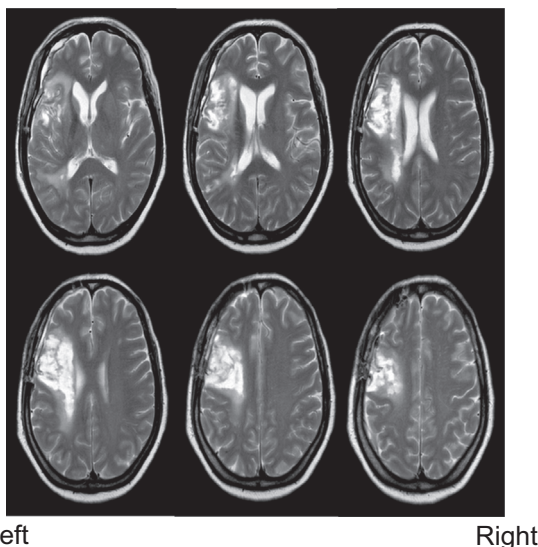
T2-weighted images in a brain MRI scan at one month after craniotomy for clipping of the aneurysm.
